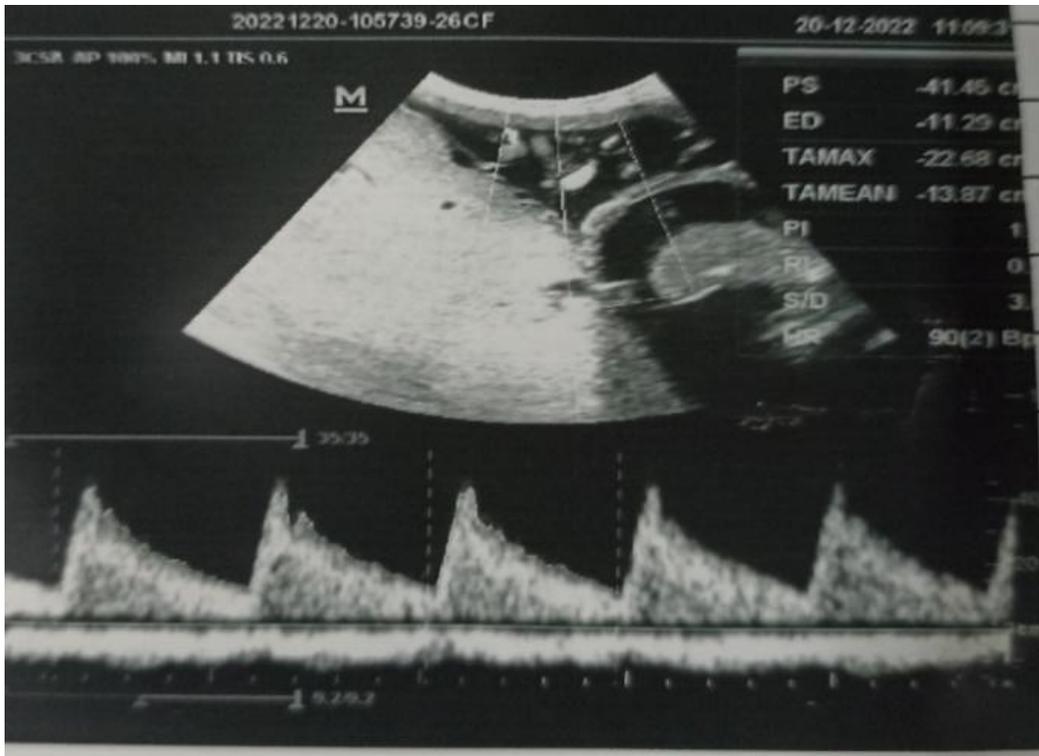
Umbilical artery doppler
